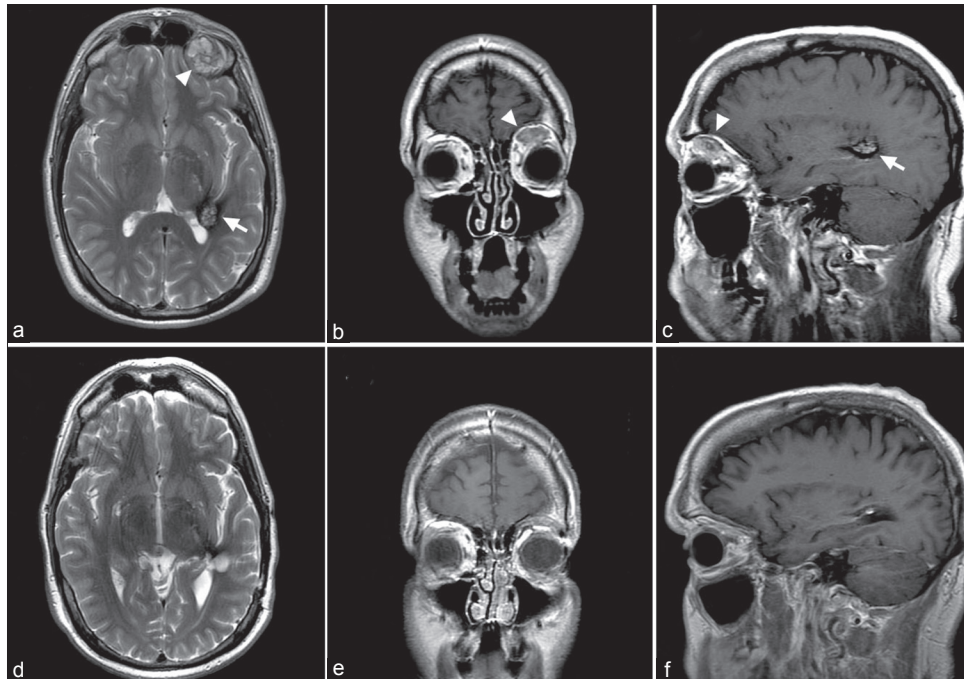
MRI of the CCM and OCH pre- and post-resection (at 3-year follow-up). (a) Axial T2 MRI showing left temporal heterogeneous popcorn lesion (arrow) extending into the atrium of the left occipital horn of the lateral ventricle consistent with a CCM. A left orbital lesion consistent with an orbital hemangioma is also visualized (arrowhead). (b) Coronal T2 image showing OCH. (c) Sagittal T1 image showing the CCM and OCH before resection. (d-f) Axial T2, coronal T2, and sagittal T1 MRIs post-resection demonstrating complete resection of the CCM and OCH
